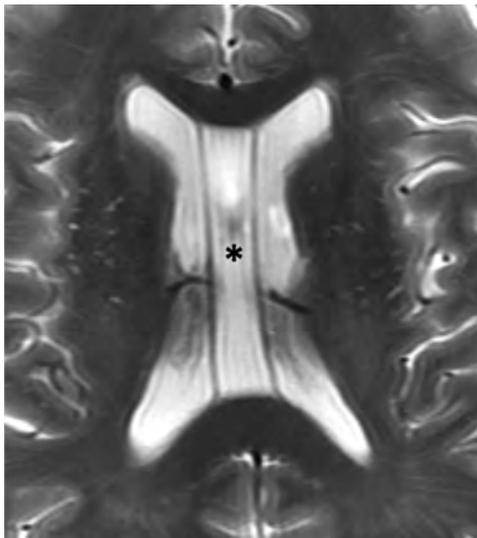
Cavum septi pellucidum and vergae. Axial T2-weighted MR image of a 67-year-old man demonstrating expansion of the cavum septi, consistent with cavum septi pellucidum (*asterisk*). There is extension posterior to the vertical plane of the columns of the fornix (not shown here) consistent with coexisting cavum vergae.
